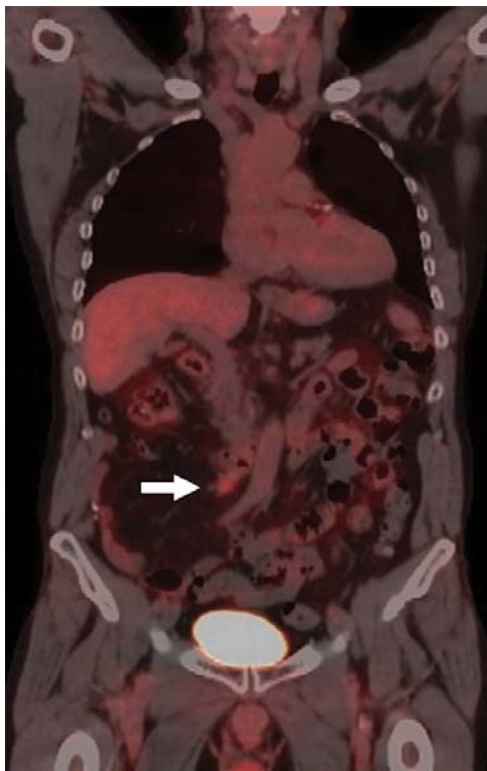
A complex case of peritoneal deposit. Coronal fused PET/CT image shows peritoneal deposit (arrow) separate from inferior vena cava and abutting inferior aspect of duodenum.
